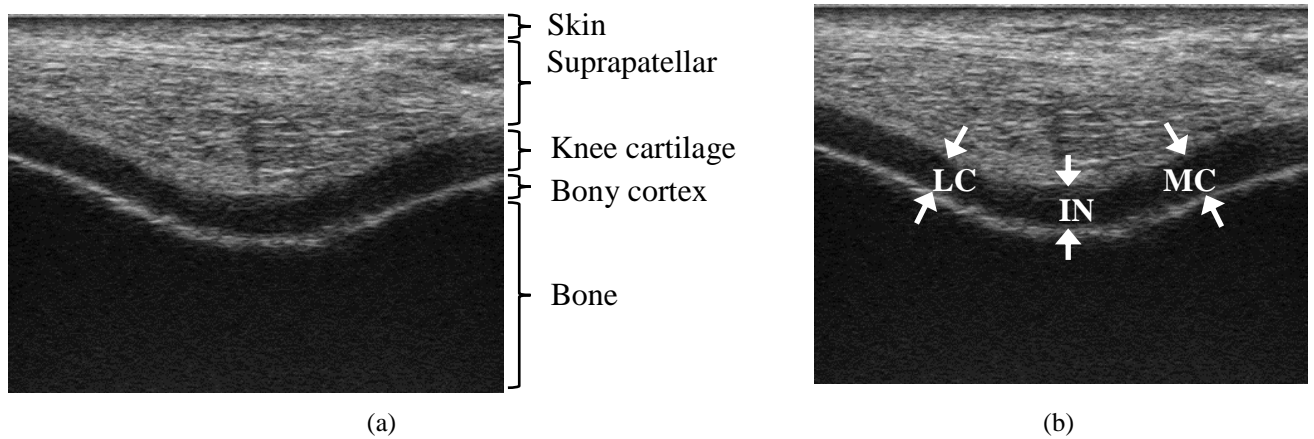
(a) Representation of knee anatomy on knee ultrasound. (b) Measurement of femoral articular cartilage thickness at intercondylar notch (IN), lateral condyle (LC), and medial condyle (MC).
